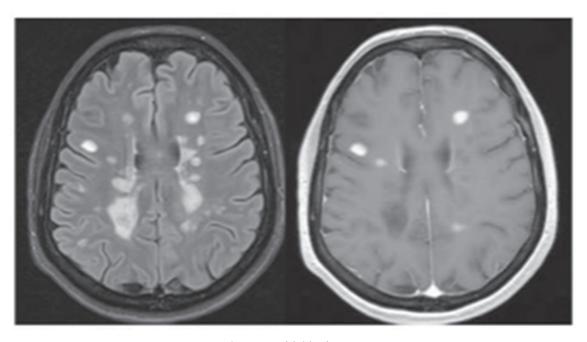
Initial brain MRI
